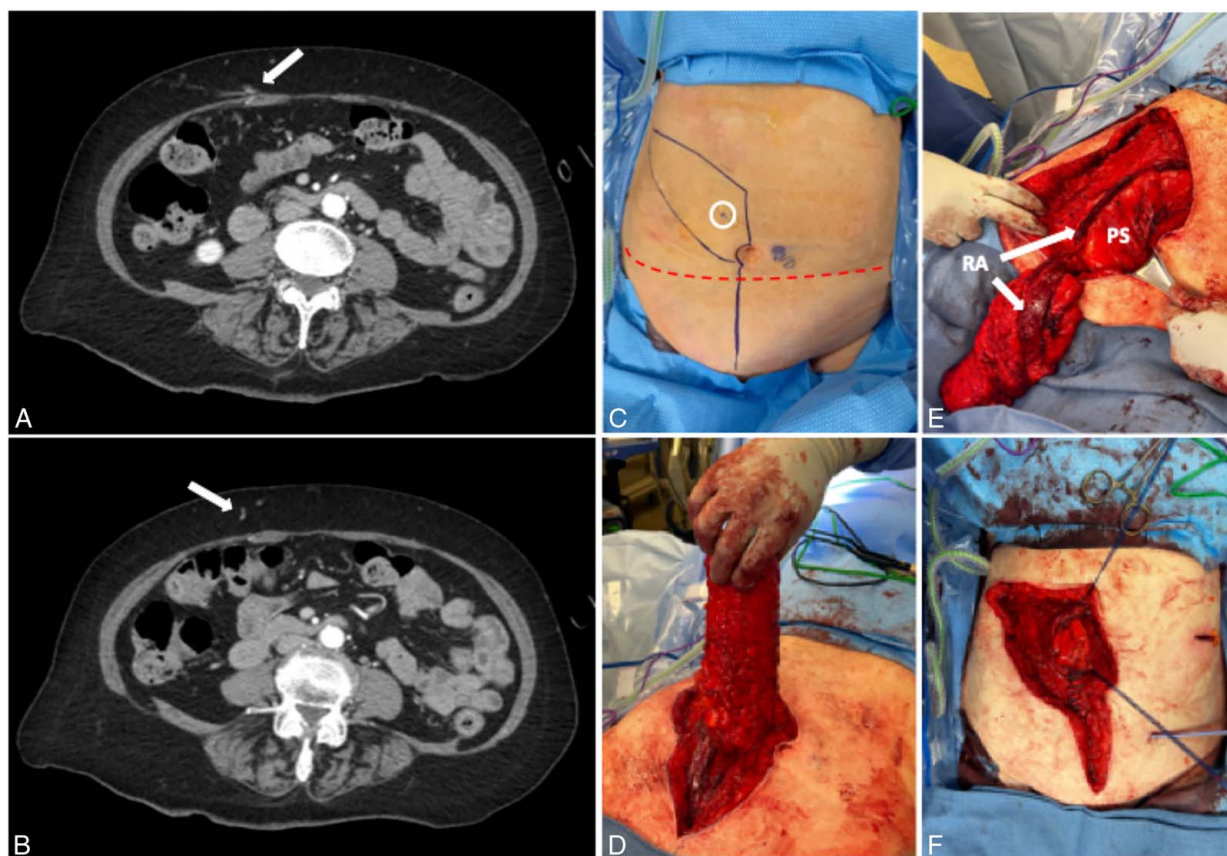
Preoperative planning and intraoperative dissection of the oblique rectus abdominis myocutaneous (ORAM) flap. A and B, Demonstrate the computed tomography visualized, large skin perforator on the right hemiabdomen (white arrow). This perforator was then easily appreciated by Doppler at bedside in the preoperative area and marked. C, Demonstrates the intraoperative skin markings of the Doppler signal (white circle) and ORAM skin paddle where the width is determined by primary donor site closure. The red dotted line marks the prior panniculectomy incision. D, Demonstrates the raised and de-epithelialized ORAM. E, The ORAM flap is reflected inferiorly to display the deep anatomy, cut aspect of the rectus abdominis (RA) and intact posterior sheath (PS). F, Displays Duramesh fascial closure of the laparotomy to minimize a future ventral wall hernia of the donor site.
